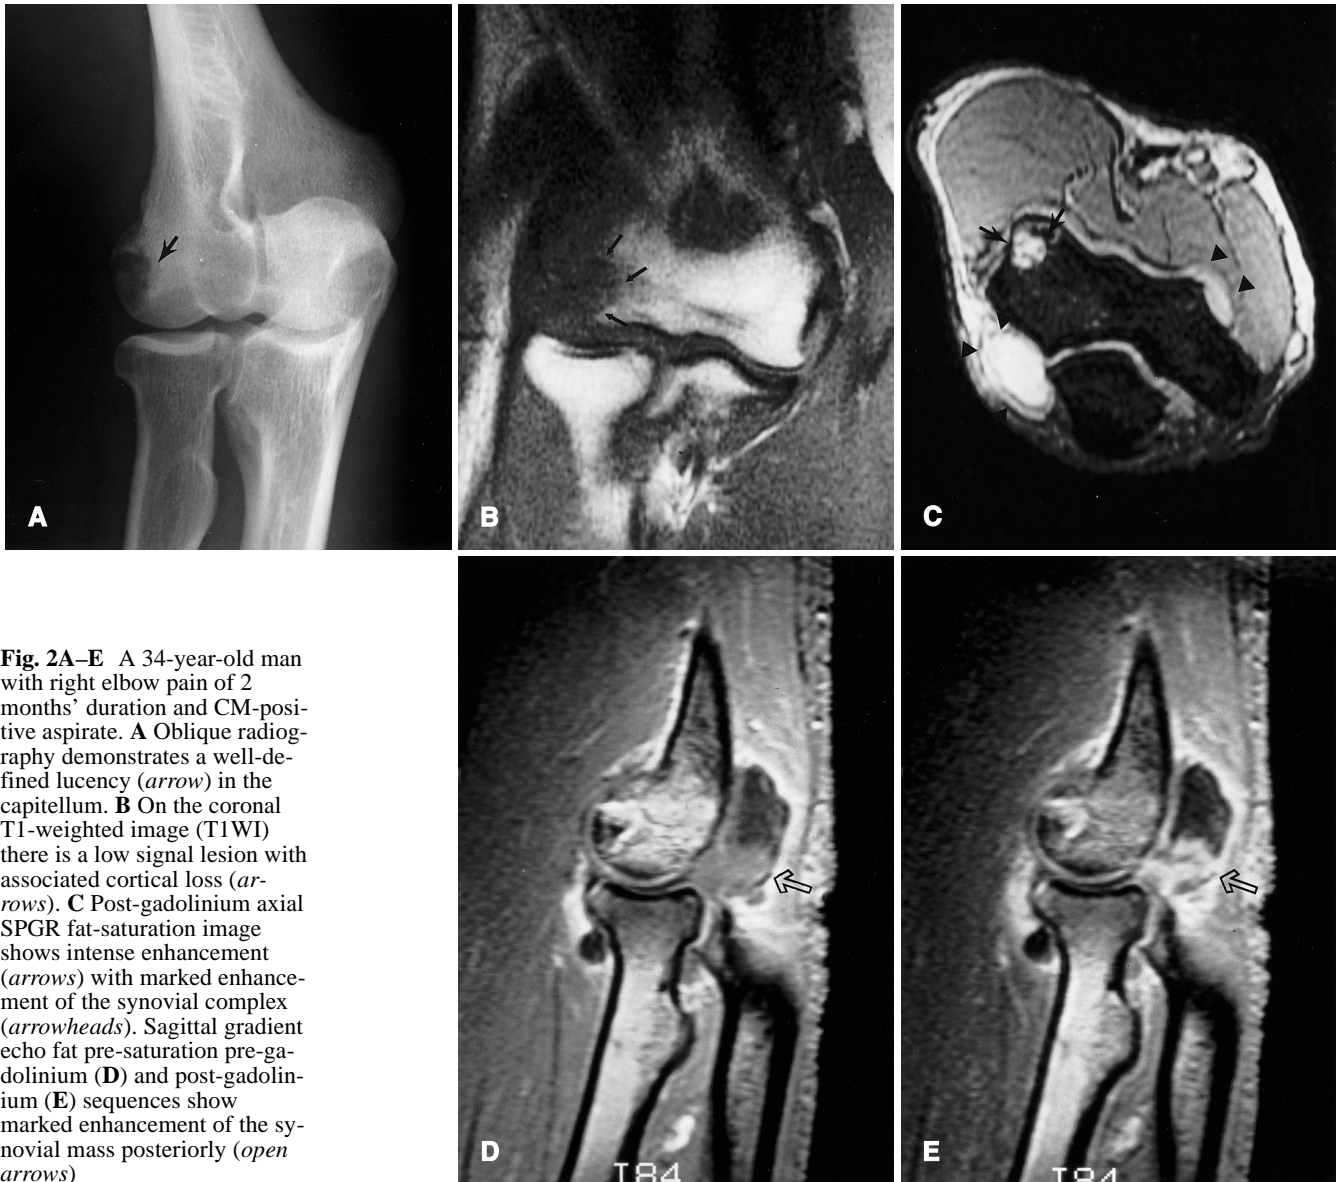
A 34-year-old man with right elbow pain of 2 months' duration and CM-positive aspirate. A Oblique radiography demonstrates a well-defined lucency (*arrow*) in the capitellum. B On the coronal T1-weighted image (T1WI) there is a low signal lesion with associated cortical loss (*arrows*). C Post-gadolinium axial SPGR fat-saturation image shows intense enhancement (*arrows*) with marked enhancement of the synovial complex (*arrowheads*). Sagittal gradient echo fat pre-saturation pre-gadolinium (D) and post-gadolinium (E) sequences show marked enhancement of the synovial mass posteriorly (*open arrows*)
